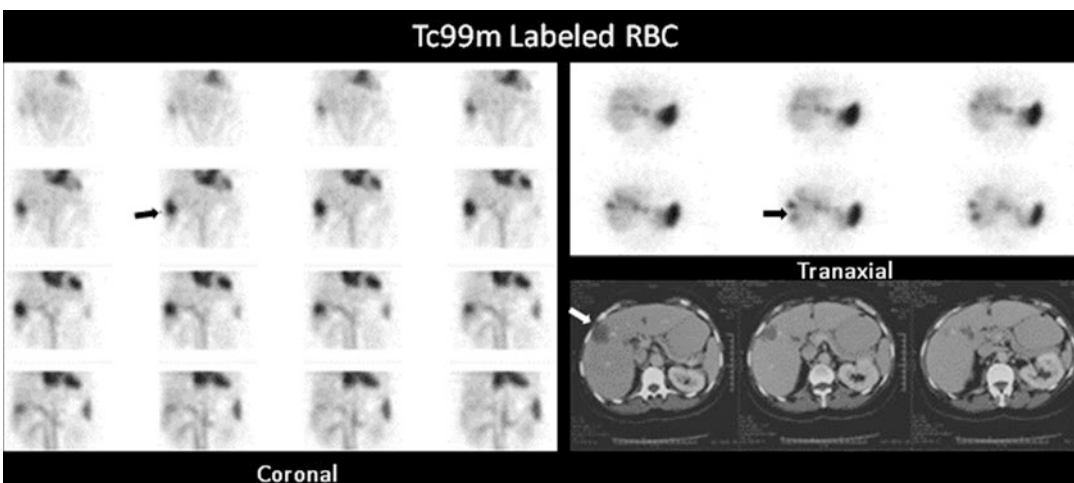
Representative images of a tomographic radionuclide hemangioma study showing a solitary hemangioma (*arrow*) corresponding to the finding on CT but clarifying its nature with high specificity
